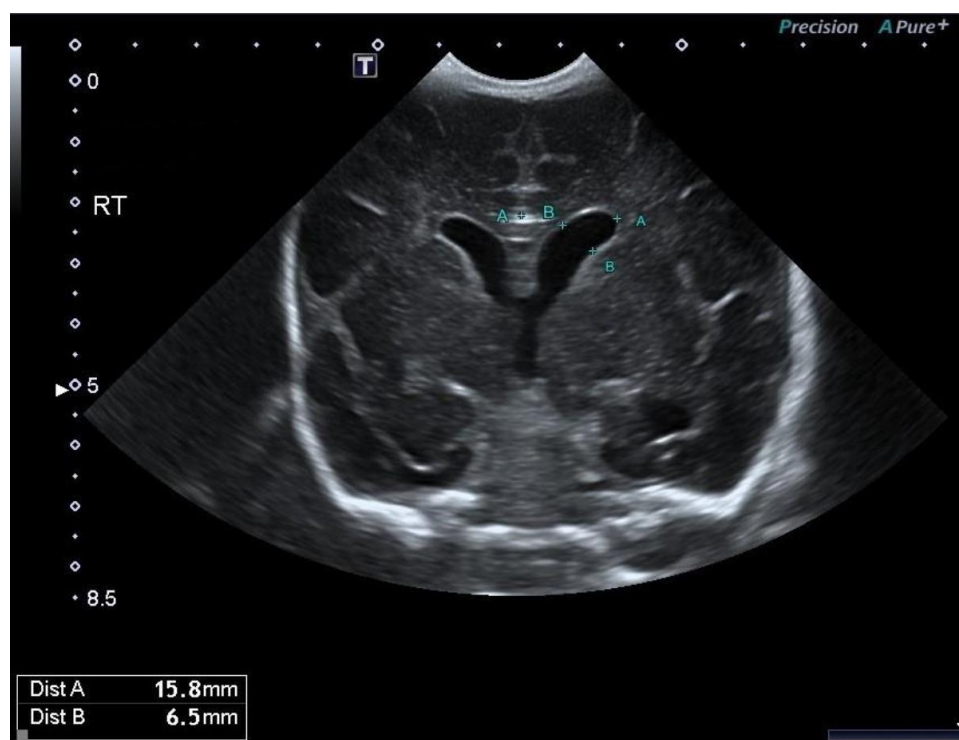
Ultrasound scan in the coronal plane at the level of the foramen of Monro showing the Rickham width (distance AA) and diagonal width of the frontal horn (distance B)
